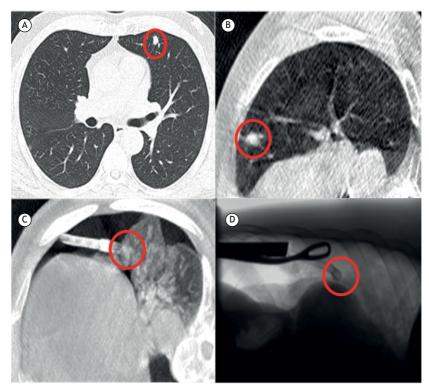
Case 2: In A, a preoperative CT scan. In B, an intraoperative CT scan identifying a nodule in the inflated lung. In C, an intraoperative CT scan identifying a nodule in the collapsed lung. In D, intraoperative fluoroscopy with a probe in place, ensuring the achievement of clear margins for the previously localized nodule.
